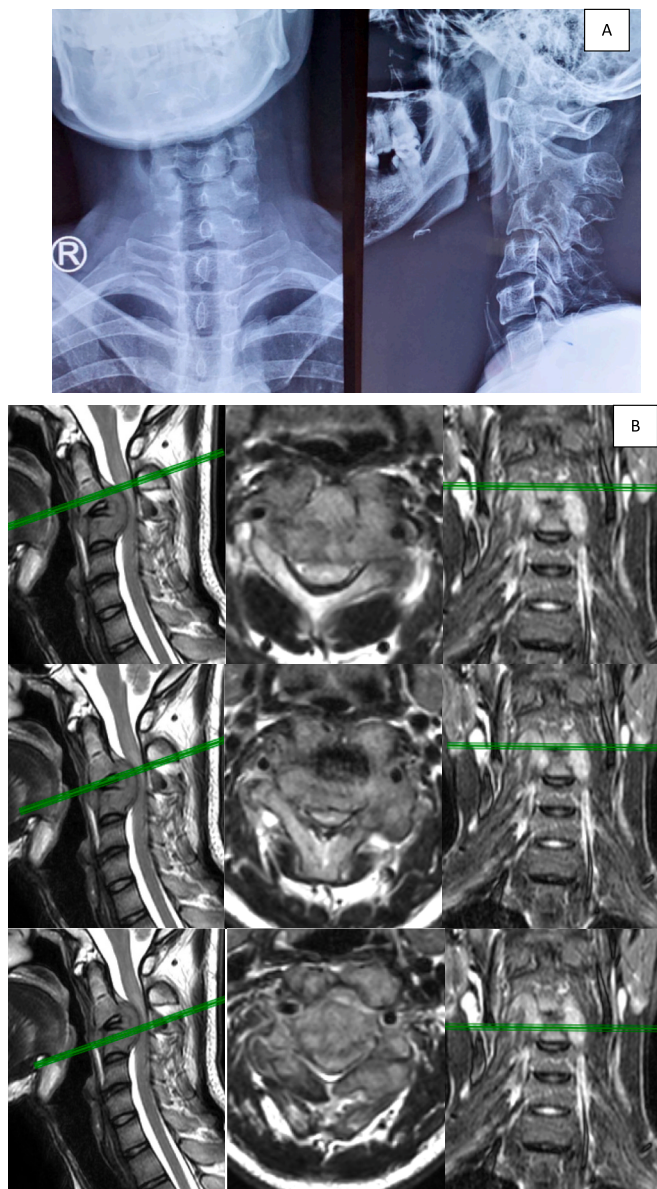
(A) Preoperative Cervical X-ray Anterior-Posterior and Lateral View, (B) Preoperative Non-Contrast Cervical MRI in V2-V4.
